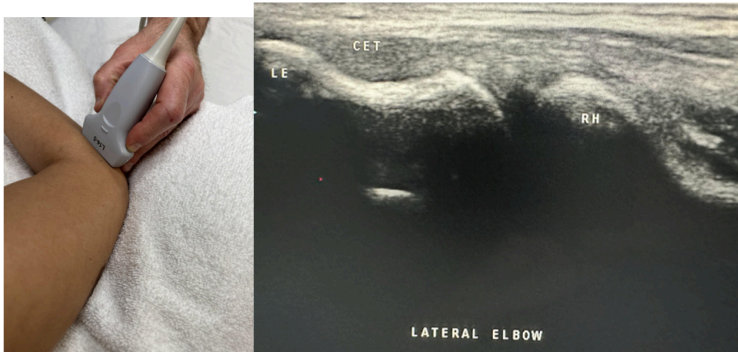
Side-by-side pictures of the transducer position and a longitudinal image of the lateral elbow showing the common extensor tendon (CET), lateral epicondyle (LE), and radial head (RH). The abbreviations given here and labeled on the ultrasound image represent the corresponding structures.
